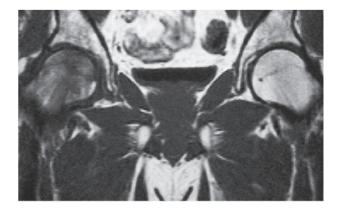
Bone marrow oedema MRI showing the typical diffuse area of low signal intensity in the right femoral head in the T1 weighted image.
